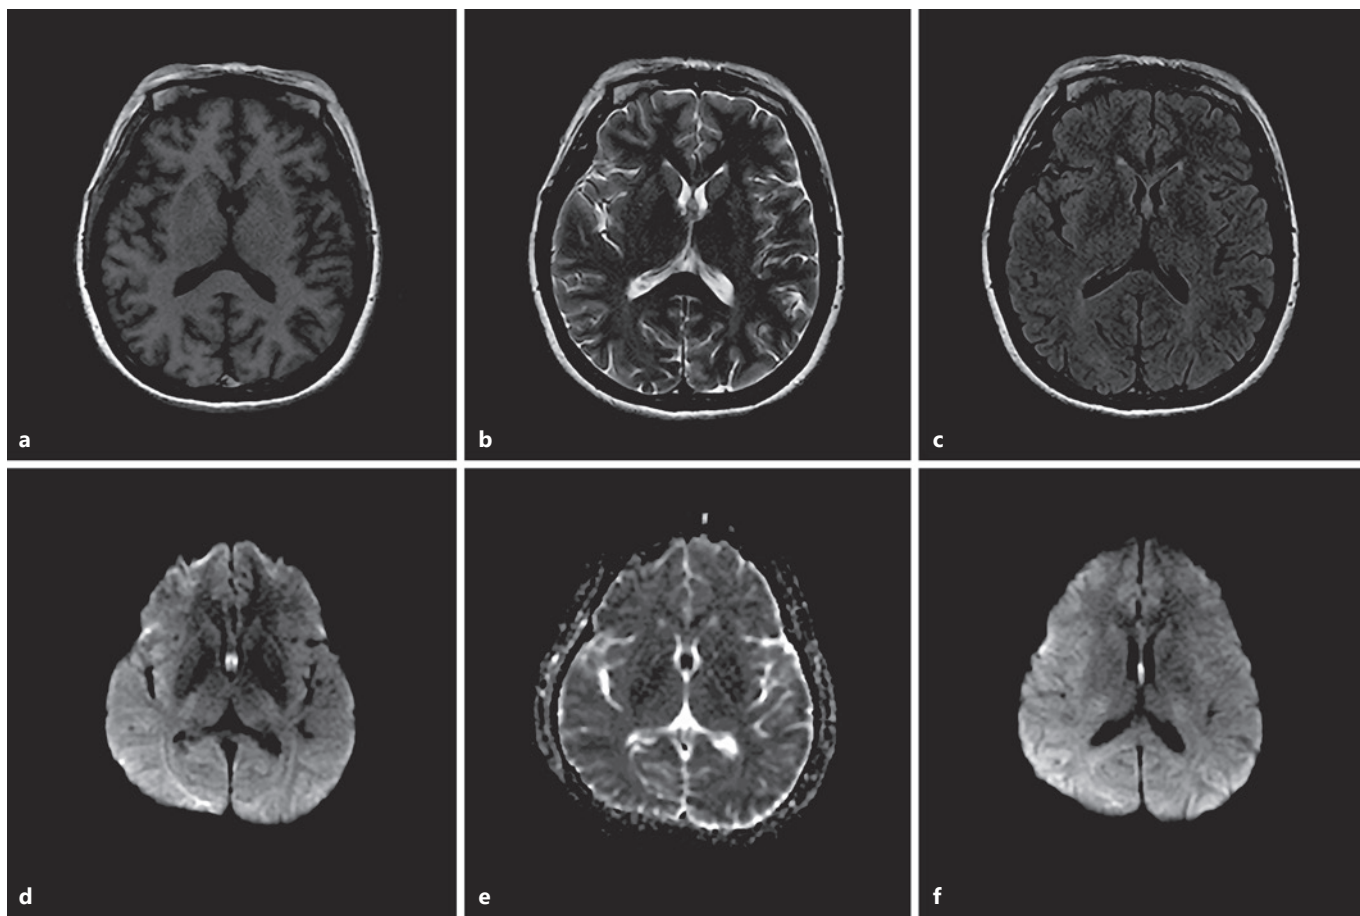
Brain MRI of the fornix. Brain axial T1-weighted imaging (a) shows hypointensities in the bilateral fornix columns, with hyperintensities on T2-weighted (b) and fluid-attenuated inversion recovery imaging (c). Axial diffusion-weighted imaging (d, f) demonstrates symmetrical restricted diffusion signals in the bilateral fornix columns, with corresponding hypointensities on the apparent diffusion coefficient map (e), indicating acute infarction. MRI, magnetic resonance imaging.
